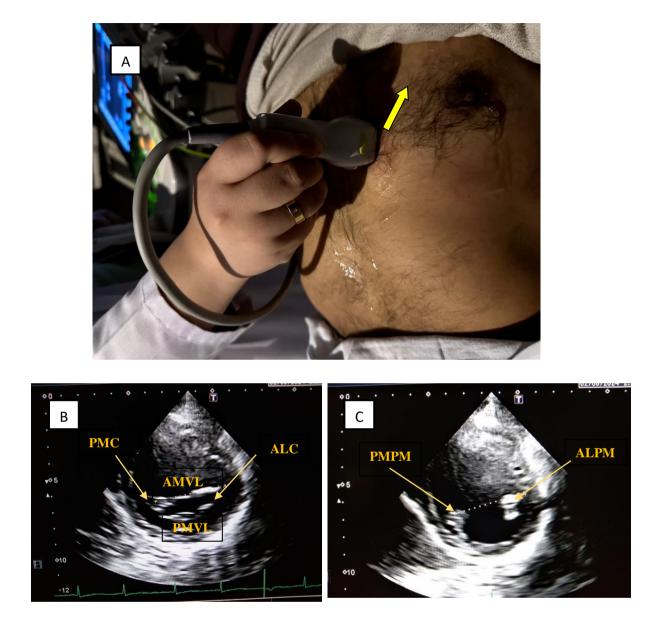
(A) Transducer position for a parasternal short-axis view. (B) Echocardiographic image for parasternal shot-axis view at the level of the mitral valve. (C) Echocardiographic image for parasternal shot-axis view at the level of the papillary muscles from the current study conducted at NICVD, Karachi. ALC=anterolateral commissure, PMC=posteromedial commissure; AMVL=anterior mitral valve leaflet, PMVL=posterior mitral valve leaflet, ALPM=anterolateral papillary muscle, PMPM=posteromedial papillary muscles.
